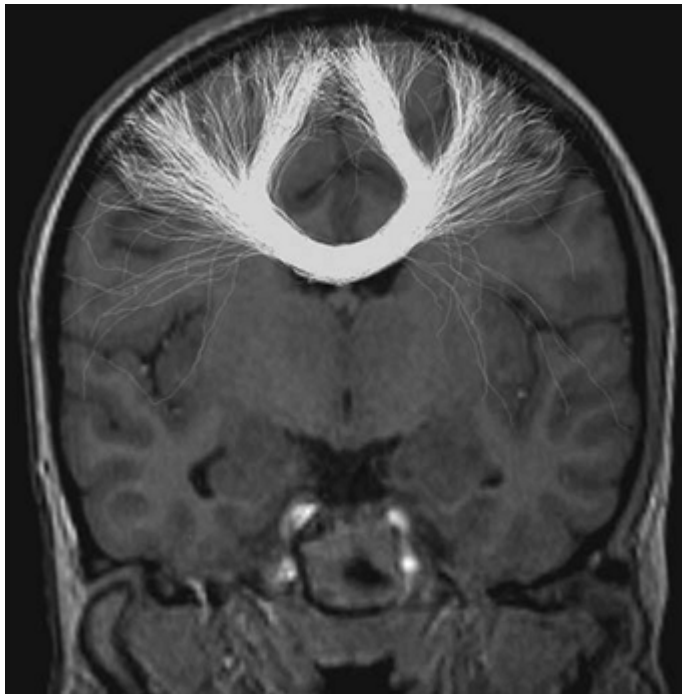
White matter tracts delineated using diffusion-weighted magnetic resonance imaging (MRI) fiber tracking, superimposed on a T1-weighted coronal MR image. The tracks were generated from a seed point in the body of the corpus callosum, using a probabilistic streamlines tracking algorithm. To allow tracking through crossing fiber regions, the directional information was obtained from the diffusion-weighted images using constrained spherical deconvolution (CSD). (Image courtesy of J-Donald Tournier, Brain Research Institute, Melbourne, Australia.)
